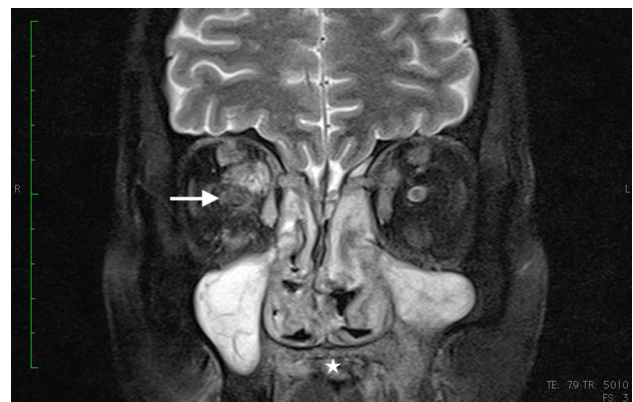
Fat suppressed T2 coronal MRI showing extensive involvement of right orbit including extra-ocular muscles and optic nerve (white arrow). In addition, note the hypointense shadow involving hard palate (starmark)
